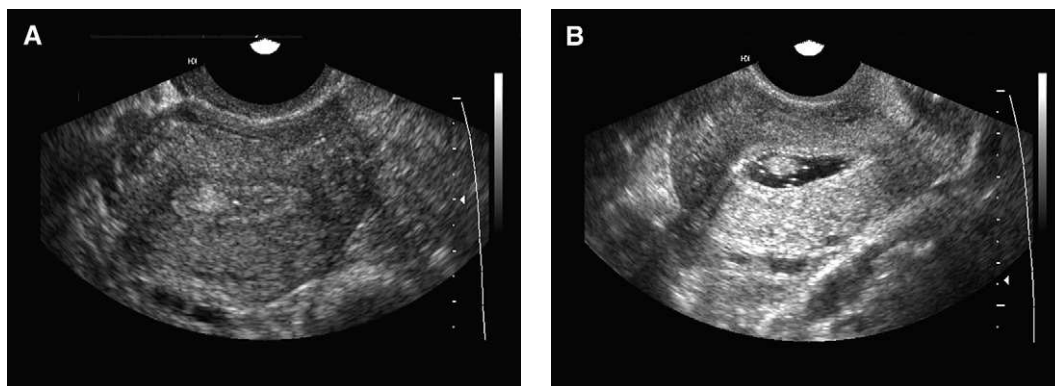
(A) Transverse ultrasound image demonstrates a small focal echogenicity within the endometrium consistent with a small polyp. (B) The corresponding saline infusion sonohysterogram image demonstrates the small sessile polyp seen on the transvaginal ultrasound image.
